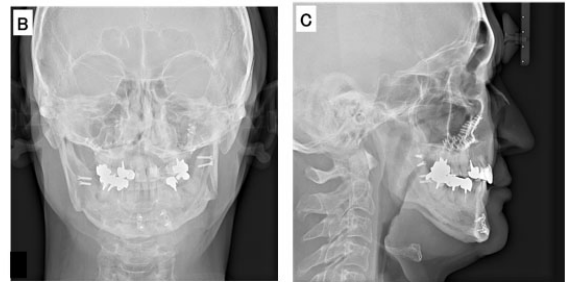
Panoramic radiograph showing the continued absence of several teeth, consistent with previous findings (A). Frontal (B) and lateral (C) cephalograms showing improvements in maxillary occlusal cant, mandibular deviation, and maxillo-mandibular retrusion.
